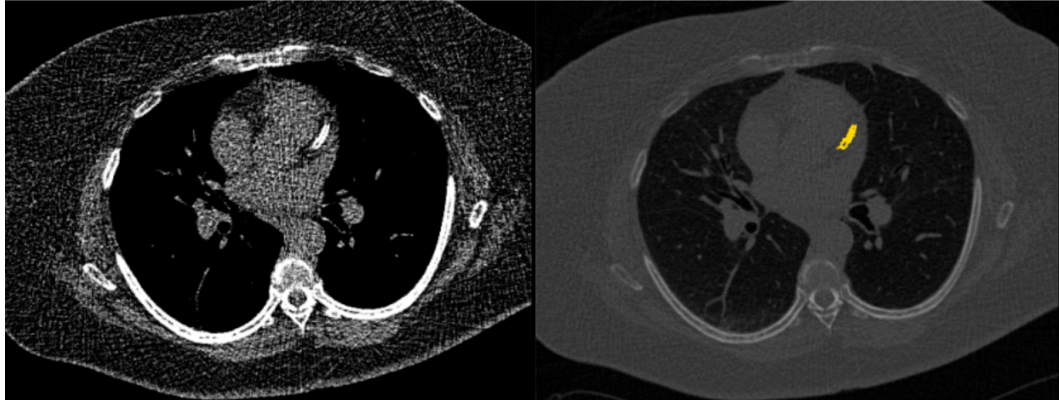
An example demonstrating a false positive calcified region by the Imbio CAC software. In this example, a stent is falsely classified as an arterial calcification. The original CT image (left) is displayed next to the RGB-overlay output from the Imbio CAC software (right) with the false positive results showing the stent as a calcified region (highlighted in yellow).
